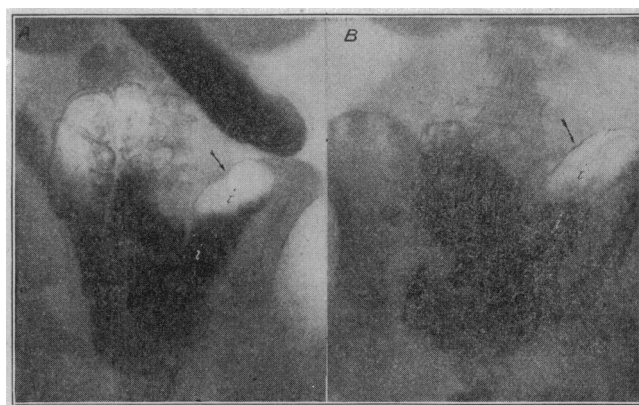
Roentgenogram showing distended ileum which commonly follows ileocolostomy: *A*, ileum distended with gas and barium, immediately after one meal and twelve hours after another; *B*, barium and gas in widely distended ileum twenty-four hours after meal.
